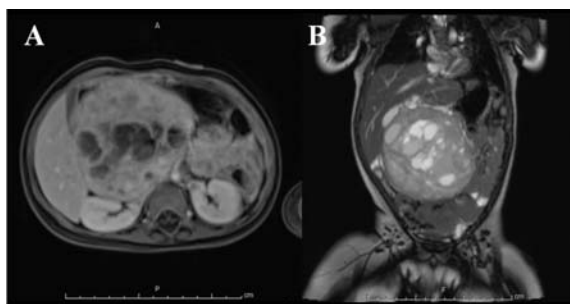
Magnetic Resonance Imaging revealed post gadolinium T1W axial view (A), and T2W coronal view (B).
